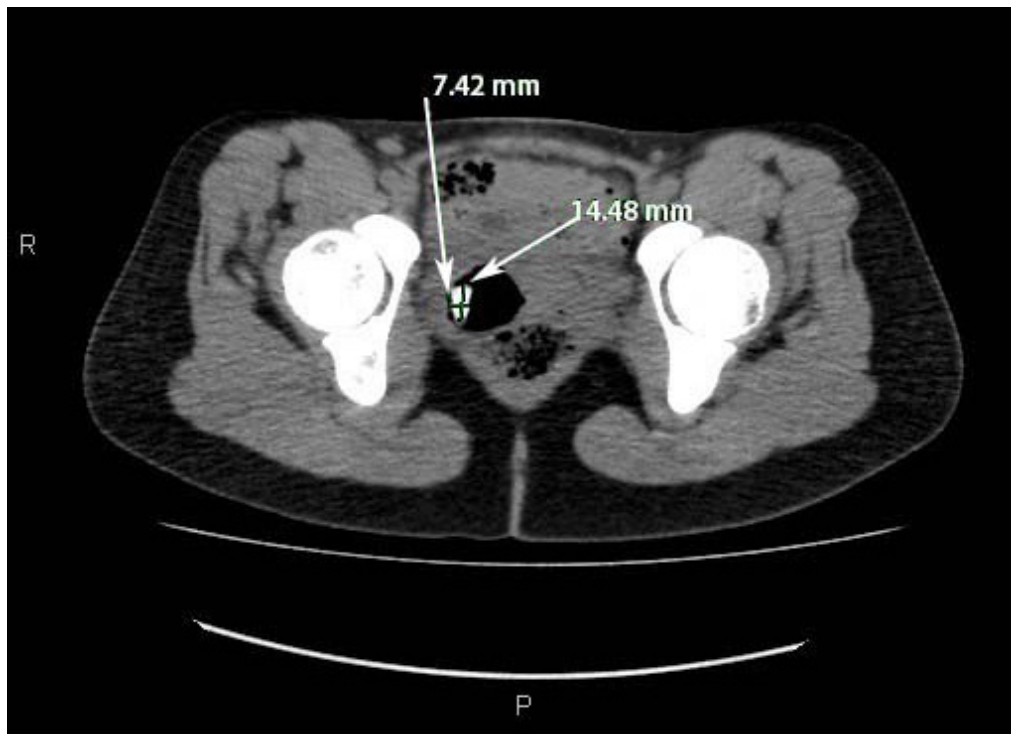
Axial computed tomography of the abdomen/pelvis with arrows revealing a tablet-like, radiopaque mass within the cervix that extends into the uterus.
